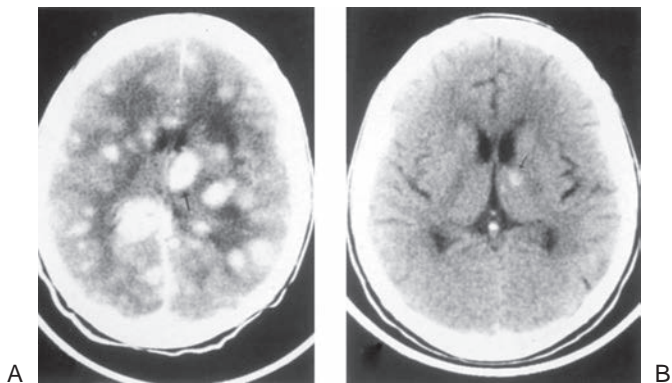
Central nervous system toxoplasmosis: magnetic resonance imaging study of the brain before therapy (A) and after therapy (B) with pyrimethamine and sulfadiazine.
